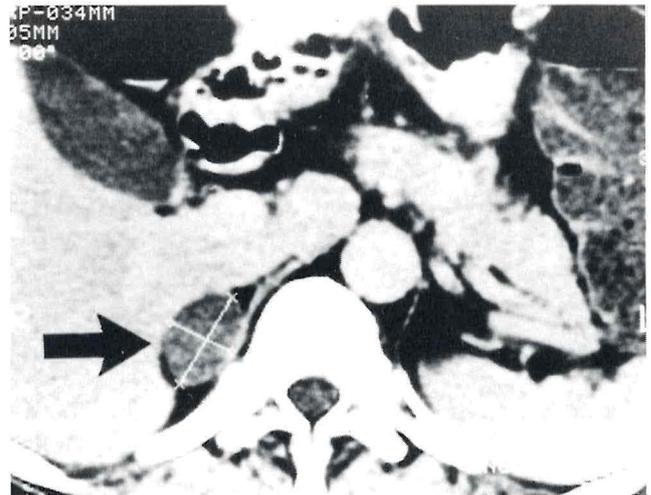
Abdominal computed tomographic scan showing adrenal tumor.
